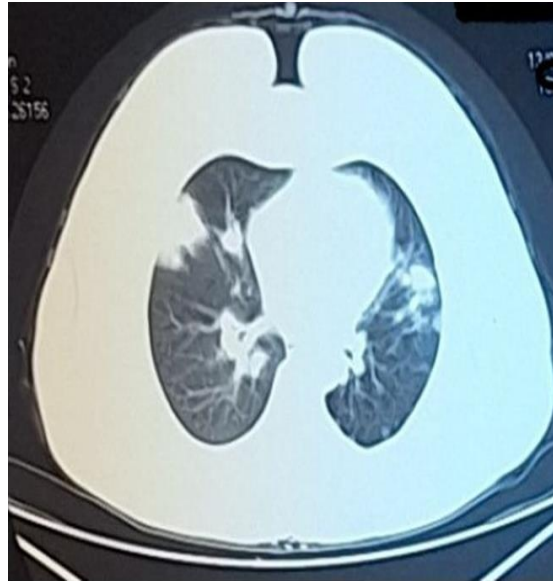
Chest CT scan showing multiple well-defined bilateral consolidations with mediastinal lymphadenopathy
